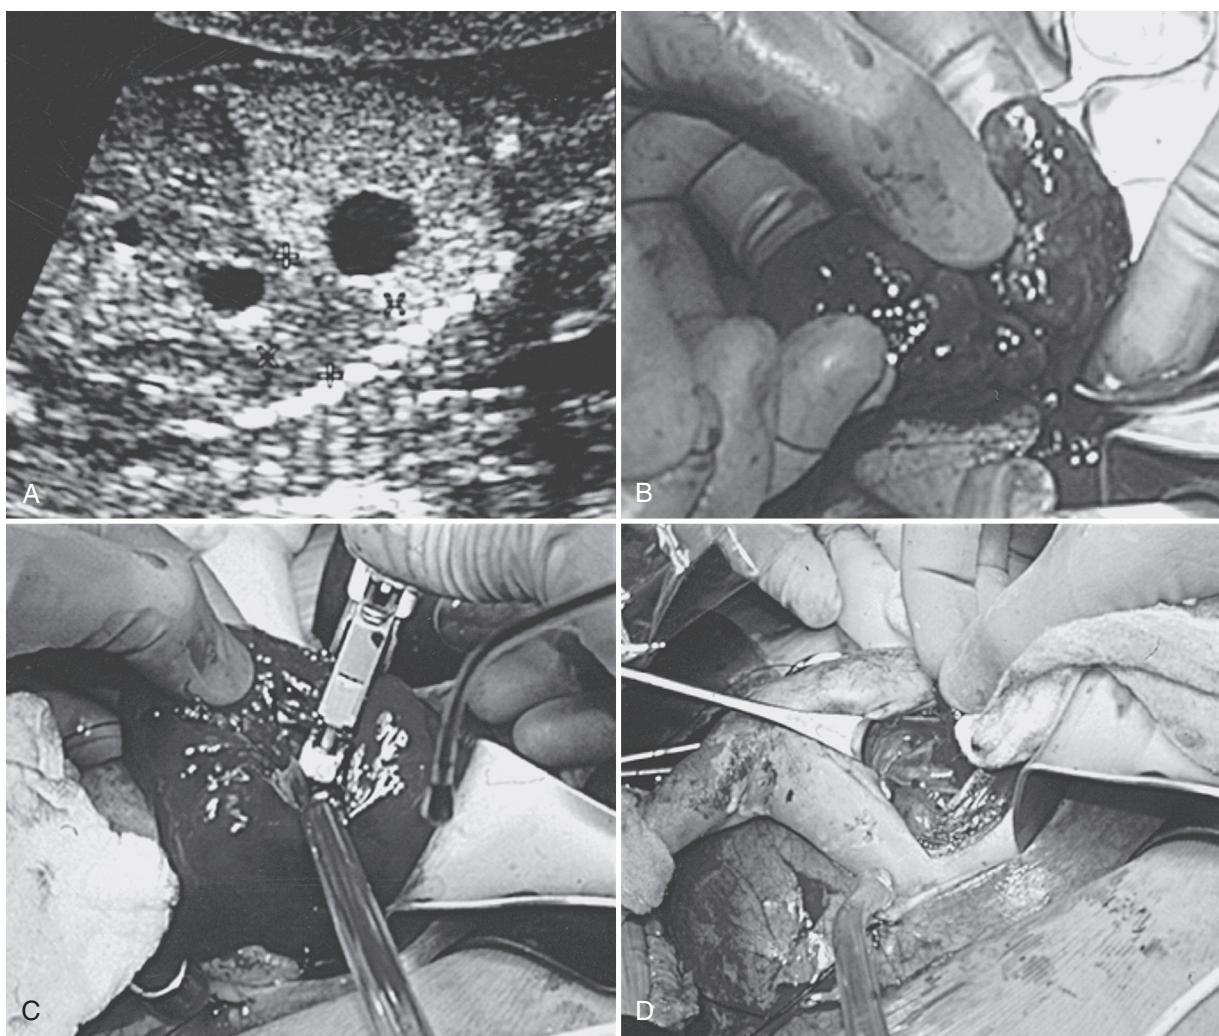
A, Fetal sonogram demonstrating an echogenic congenital pulmonary airway malformation of the lung (CPAM), with a single large cyst and compressed normal lung outlined by cursors posteriorly. B, Exposure of CPAM through fetal thoracotomy. C, Resection of CPAM from adjacent normal lung and hilum using surgical stapler. D, Fetal pleural cavity after resection of the CPAM. (From Shaaban AF, et al. The role of ultrasonography in fetal surgery and invasive fetal procedures. *Semin Roentgenol*. 1999;34:62.)
